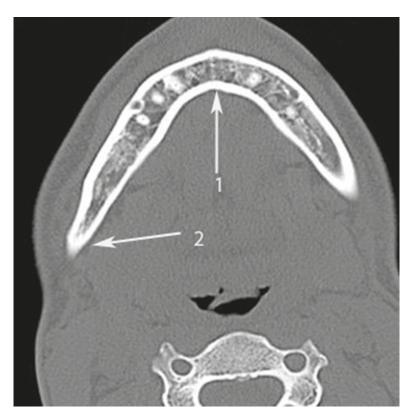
Axial CT scan at the level of the lower border of mandible. *Numbers* with *arrows* denote the following anatomical structures: 1 – the mandibular symphysis; 2 – the right mandibular ramus.
